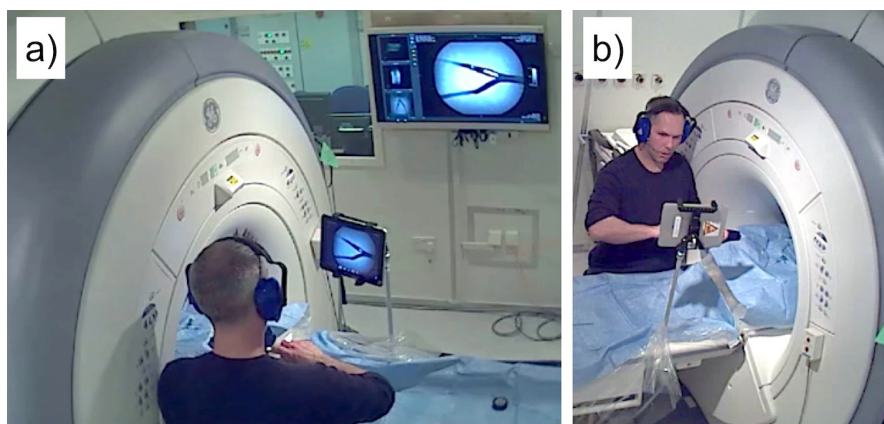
In-room iMRI display and control setup - Photographs taken during a MRI-guided iliac angioplasty procedure demonstrating the in-room iMRI display and control setup. The pictures were taken from two wireless IP cameras (M1031W, Axis, Lund, Sweden) that were installed in the scanner room. These IP cameras are designed to deliver live video through the WLAN (see Section 4.3.2) to a web browser or recording application. The picture (a) was acquired from the back and picture (b) from the front. The mobile tablet PC was mounted on an IV pole. The screen of the tablet shows the same rtMRI scene as the 40" in-room monitor. Note, the physician was able to zoom into the region of interest on the touchscreen (a).
